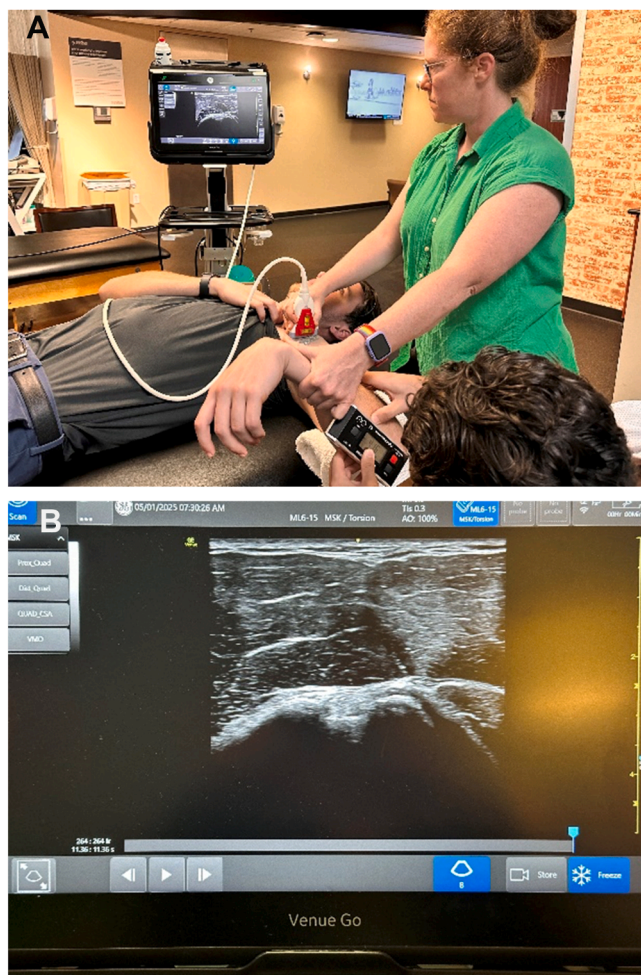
Measurement of (A) anatomic humeral retrotorsion using a linear ultrasound probe placed over the anterior shoulder and (B) visualization of the deepest portion of the bicipital groove while the lesser and greater tubercle remain parallel.
